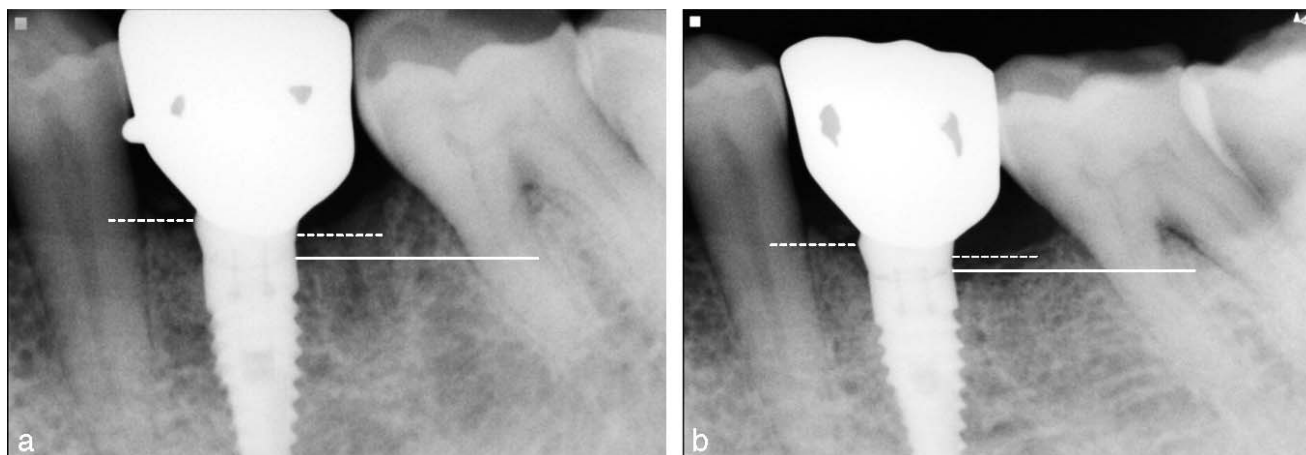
Radiographic assessment. (a) Radiographs at the time of prosthesis delivery. (b) Radiographs after 1-year follow-up (white spot lines on both sides of the implant indicate the mesial and distal bone level; white line indicates implant-abutment junction).
